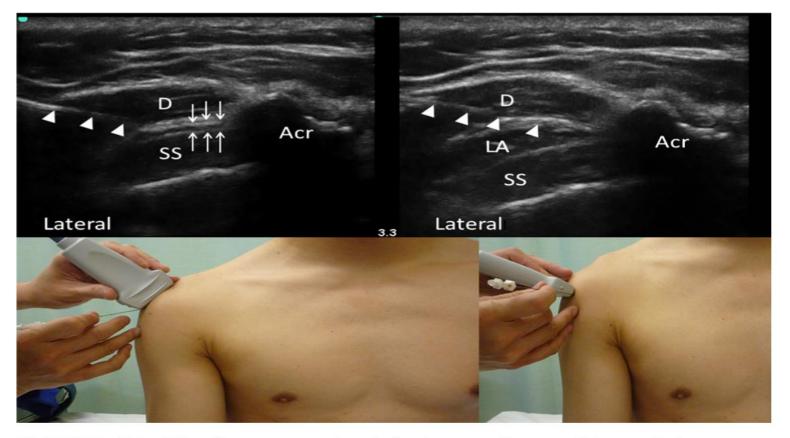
The insert on the left shows the position of the ultrasound probe and the needle with the in-plane technique. Note that the medial end of the ultrasound probe is placed over the acromion (Acr). However, in a patient with a slim body build, the probe can be placed in another orientation as shown in the right insert. The ultrasound image on the left shows the needle (arrowheads) inserted with in-plane technique to the SASDB, as highlighted by the peribursal fat (line arrows). The image on the right shows the presence of local anesthetic following the injection, with the separation of the deltoid muscle (D) and SS tendon. Reprinted with permission from usra.ca.
